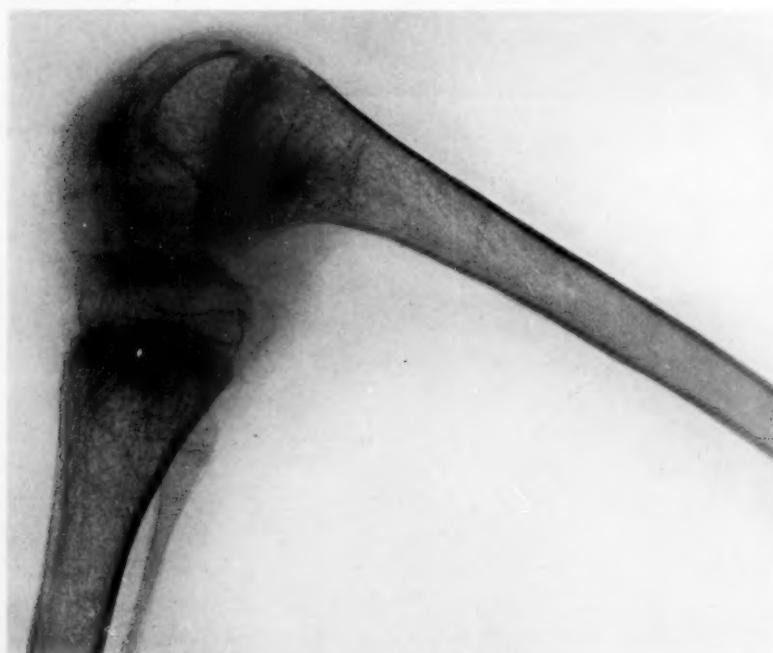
X-ray of knee-joint of preceding case. Note the marked atrophy in the bones, roughening of the joint surfaces and cloudiness of the joint capsule.
